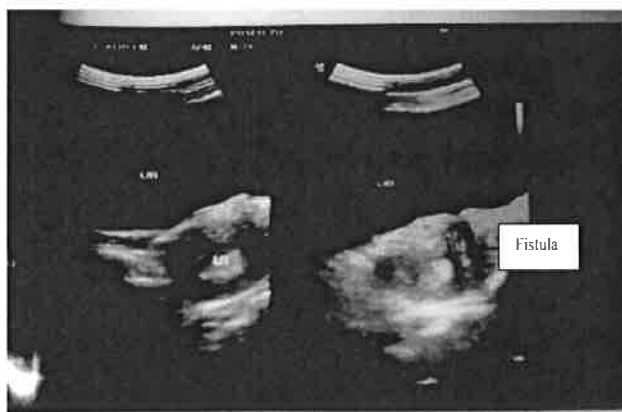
Ultrasound of vesicouterine fistula*
